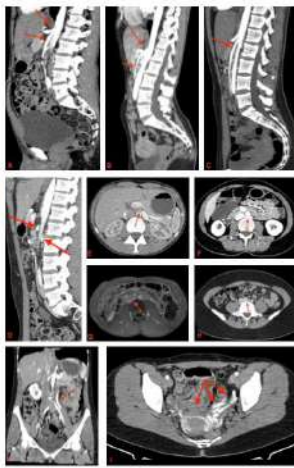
CT images of vascular compression syndromes: A) MALS, B) NRCS, C) SMAS, D) MIS, E) PVI, F) IVCS. G) MALS, H) NRCS, I) SMAS, J) MIS, K) PVI, L) IVCS.
